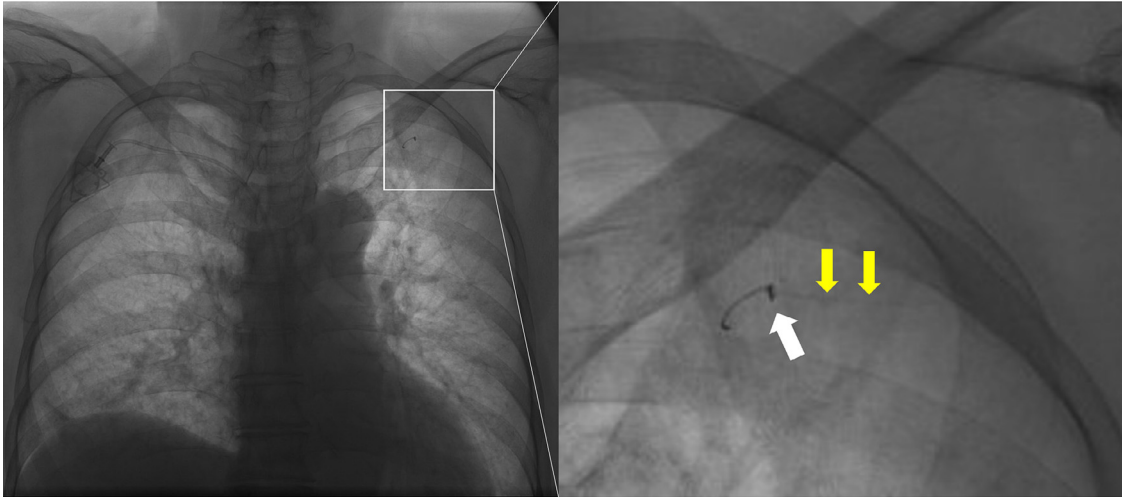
A chest X-ray after placement of a central venous port. A knot like shadow was shown near the tip of the guidewire (white arrow). The outer cover coil of the guidewire was stretched out (yellow arrows).
